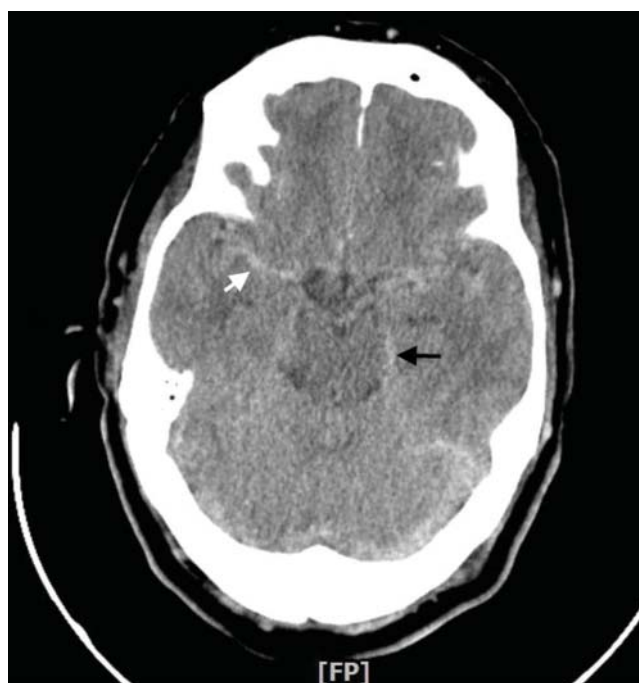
Computed tomography showed increased attenuation in the ambient cistern (black arrow) and cortical sulci (white arrow).
